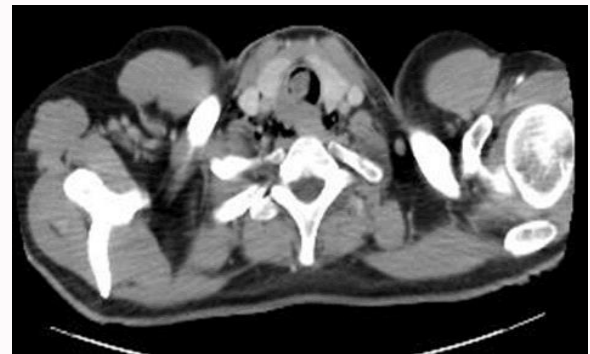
CT scan neck with reconstruction images showing irregular narrowing of tracheal lumen with growth.
